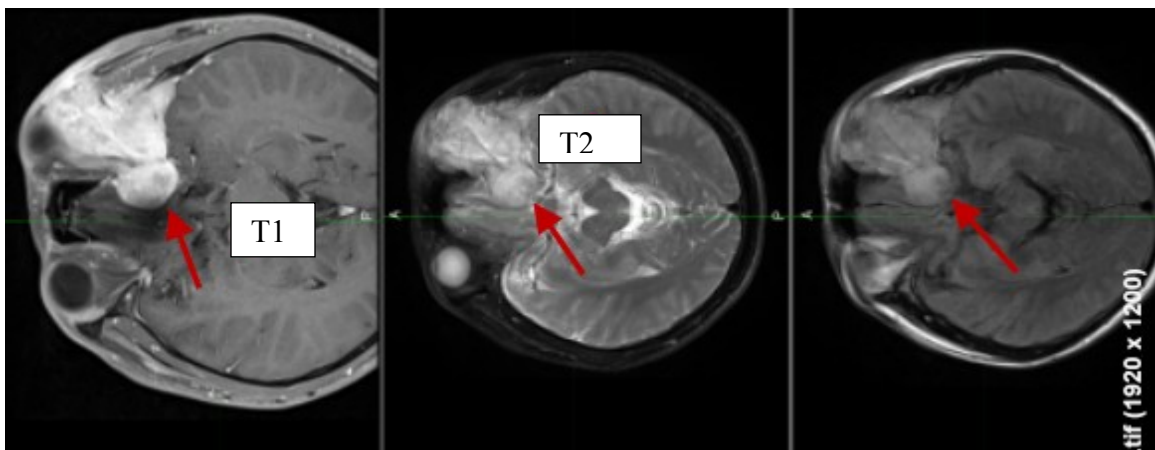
T1 and T2 images of MRI of brain
